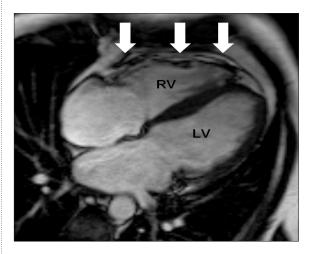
Cardiac MRI showing extensive myocardial scar and oedema in right ventricular wall (arrowed).
